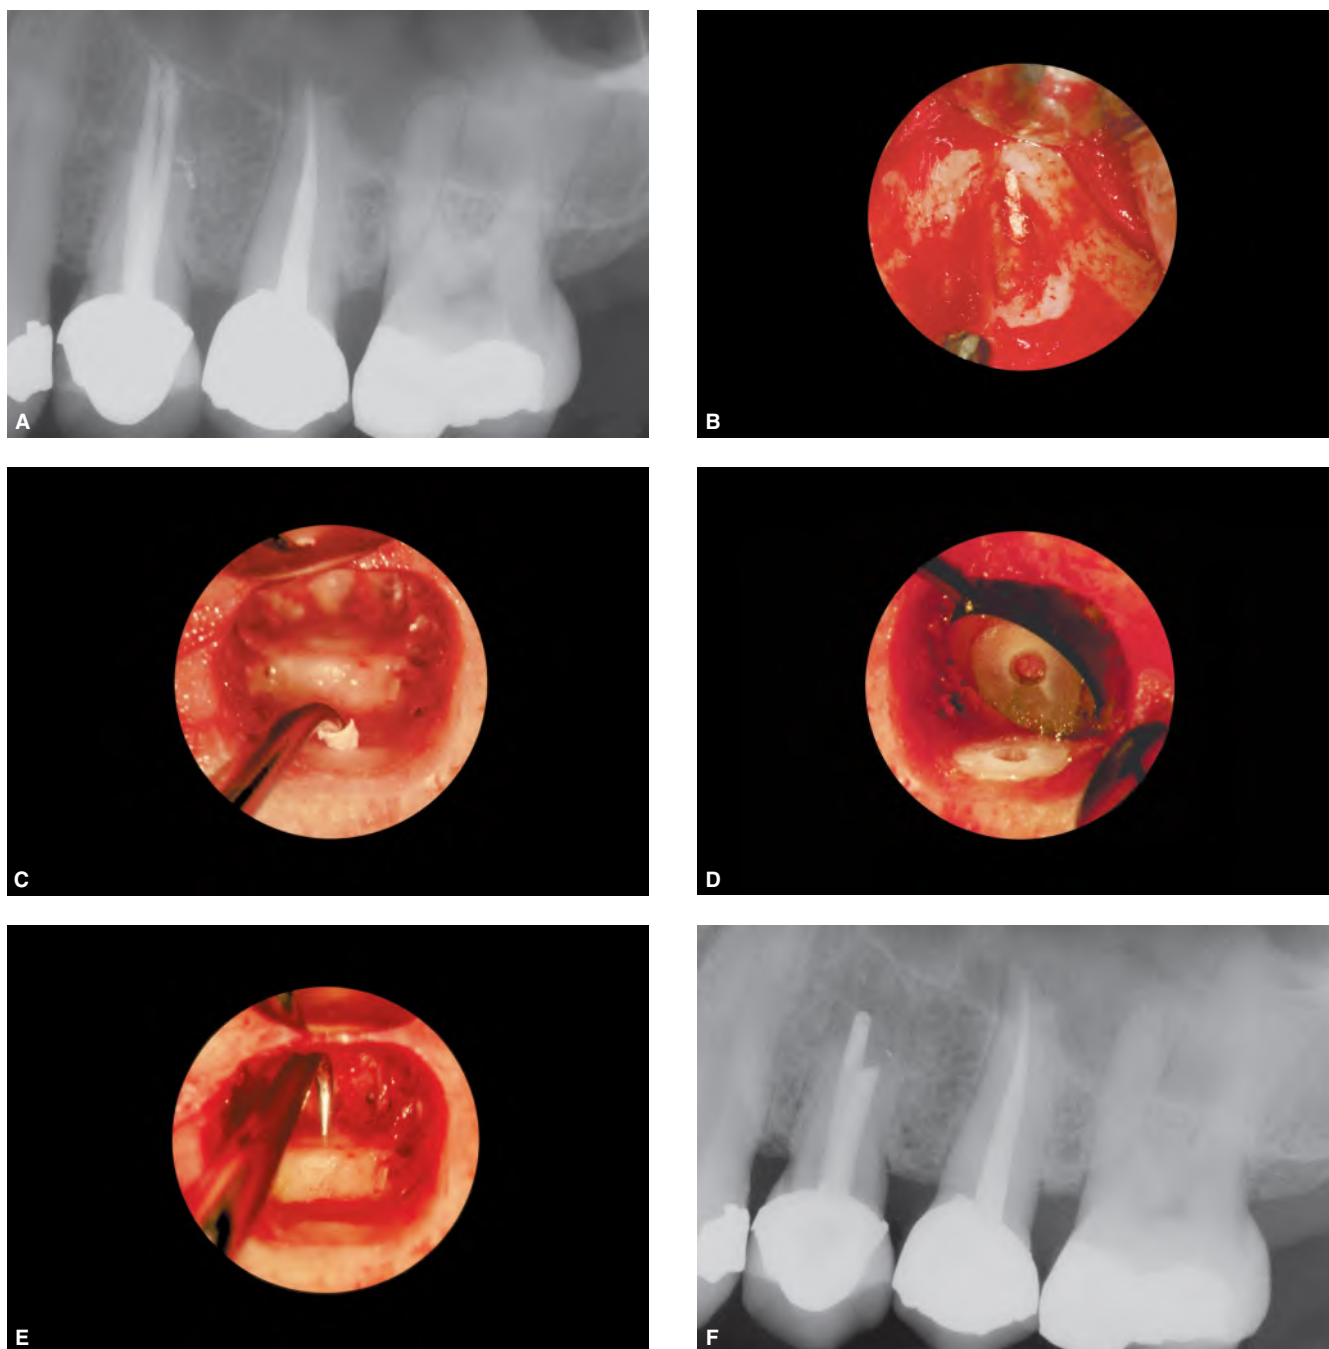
A. Preoperative radiograph of a maxillary left first premolar. Note, the packed buccal canal does not conform to the mechanical objectives of cleaning and shaping. B. Following flap elevation, a surgical photograph at 12× magnification shows gutta-percha exiting through a significantly ripped and relocated foramen. C. Surgical photograph at 12× magnification shows osteotomy, apicoectomies, and ultrasonic root-end preparation of the buccal canal. D. Surgical photograph at 12× magnification through a sapphire-plus micro-mirror depicts the finished buccal root-end preparation. E. Ultrasonic root-end preparation of the lingual canal. F. Four-year recall film showing the apically corked canals and excellent osseous repair.
